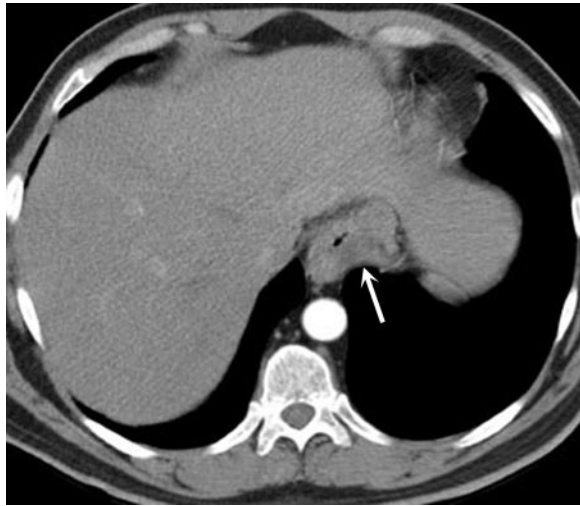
Esophageal carcinoid tumor. Contrast-enhanced CT image shows asymmetric circumferential thickening of the wall of the distal esophagus (arrow), an extremely rare site of carcinoid disease. At endoscopic biopsy, the lesion was found to be a carcinoid tumor.
